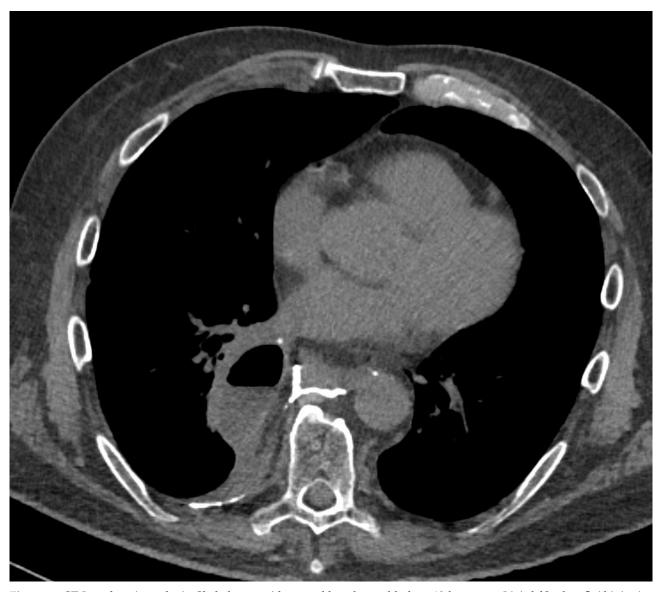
CT-Lymphangiography in Chylothorax, with stopped lymph vessel leakage 12 hours past Lipiodol® ultra-fluid injection proving therapeutic success.
